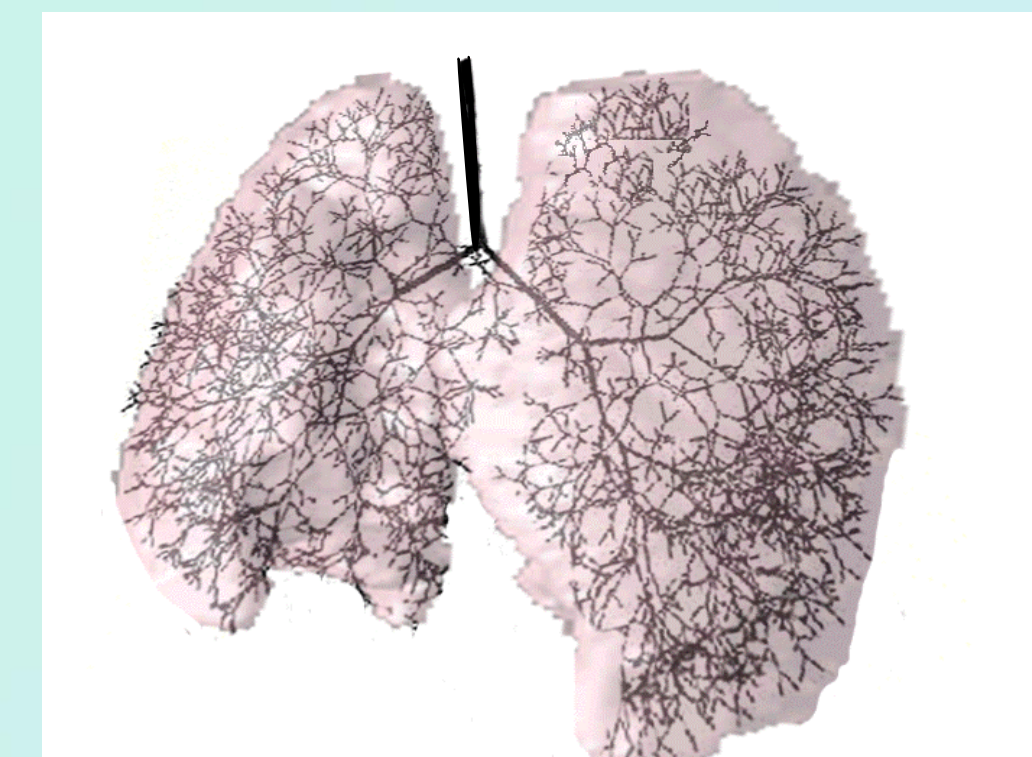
A branching lung network model bounded by the MRI-based lung model.
